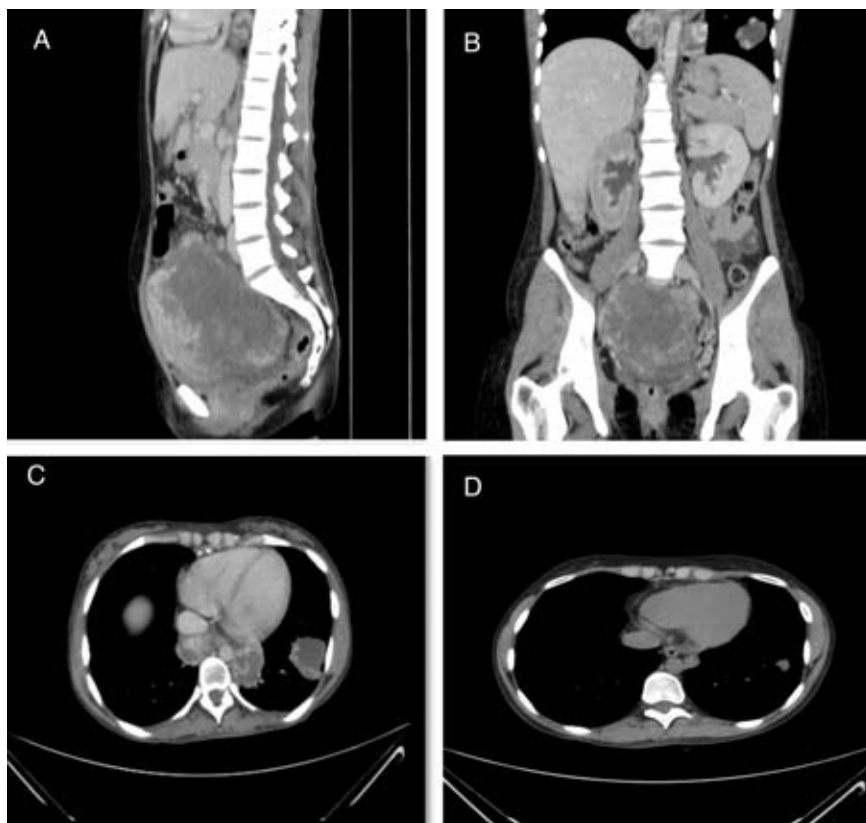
A) Extensive heterogeneous pelvic mass with peripheral enhancement and large necrotic component, measuring approximately 15.4×14.7×14.0 cm. It presents intimate contact with the bladder, ascending colon, and descending segments of the small intestine and the right iliopsoas and uterus. B) Coronal image showing bulky pelvic mass at diagnosis, showing pulmonary nodules, the largest in the left lung base measuring 3.7×3.6 cm. C) CT image during initial staging showing pulmonary metastases with heterogeneous contents and calcifications inside. D) Pulmonary metastasis after treatment with chemotherapy and surgery, measuring 10×10 mm, without the expression of serum with chemotherapy and surgery.
